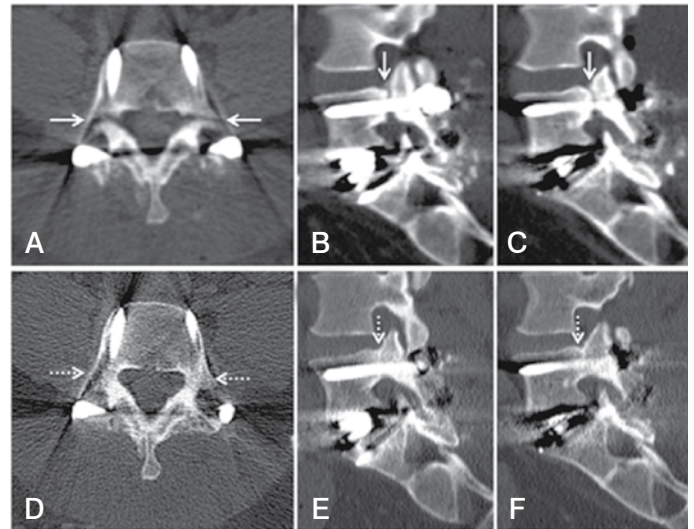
Immediate post-operative CT. A) Axial section; B) Right pedicle, sagittal view; C) Left pedicle, sagittal view. The solid arrows show the gap in the fracture. The images show the CT six months after surgery; D) Axial section; E) Right pedicle, sagittal view; F) Left pedicle, sagittal view. The dotted arrows show consolidation of the fracture lines.
